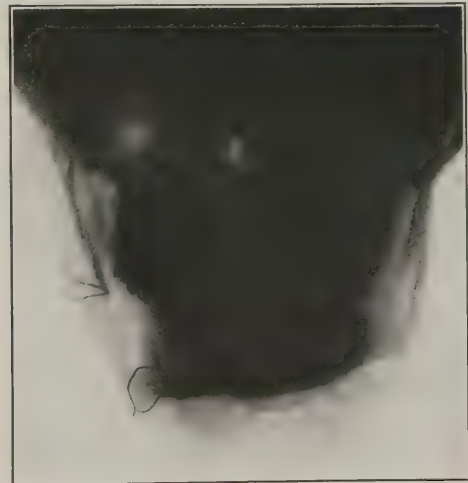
Case 11: Radiograph made three months after operation.
